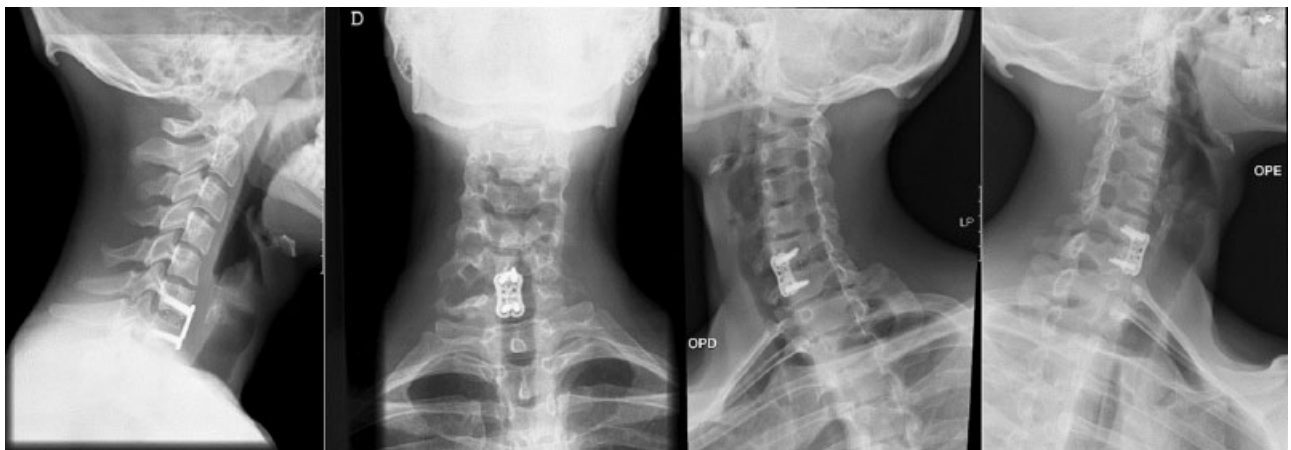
3 years follow-up cervical spine radiographs: lateral view, AP and oblique view.
